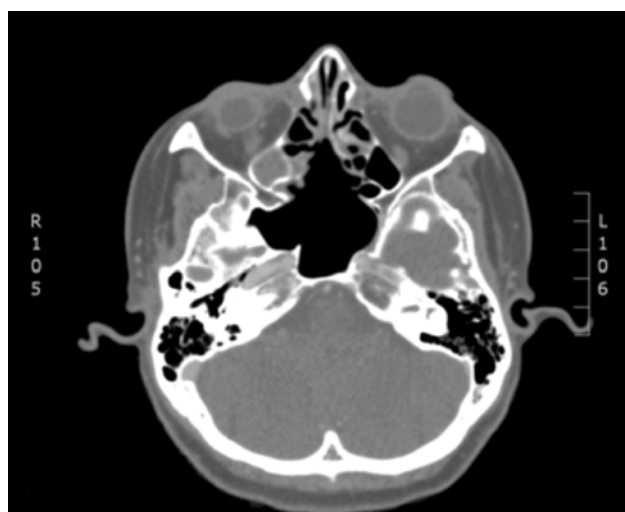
Post-operative CT scan (with contrast) showing clear sphenoid sinus.
